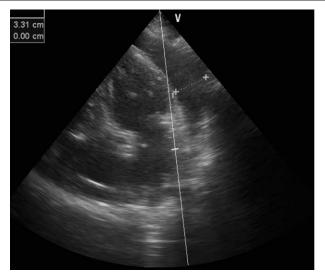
Transthoracic echocardiography in apical 4-chamber view showing pericardial effusion. The echocardiograph showed a large circumferential pericardial effusion (>25 mm at end-diastole).
